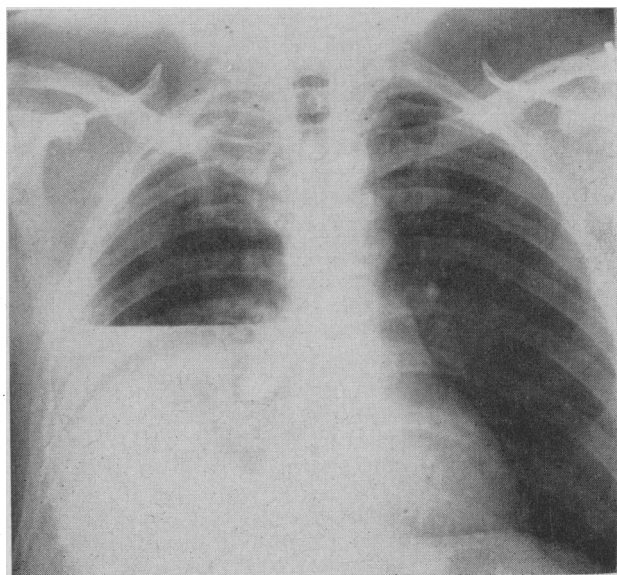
Initial chest radiograph on December 31, 1961, revealed a hydropneumothorax with a radio-opaque foreign body in the right hilar region.
